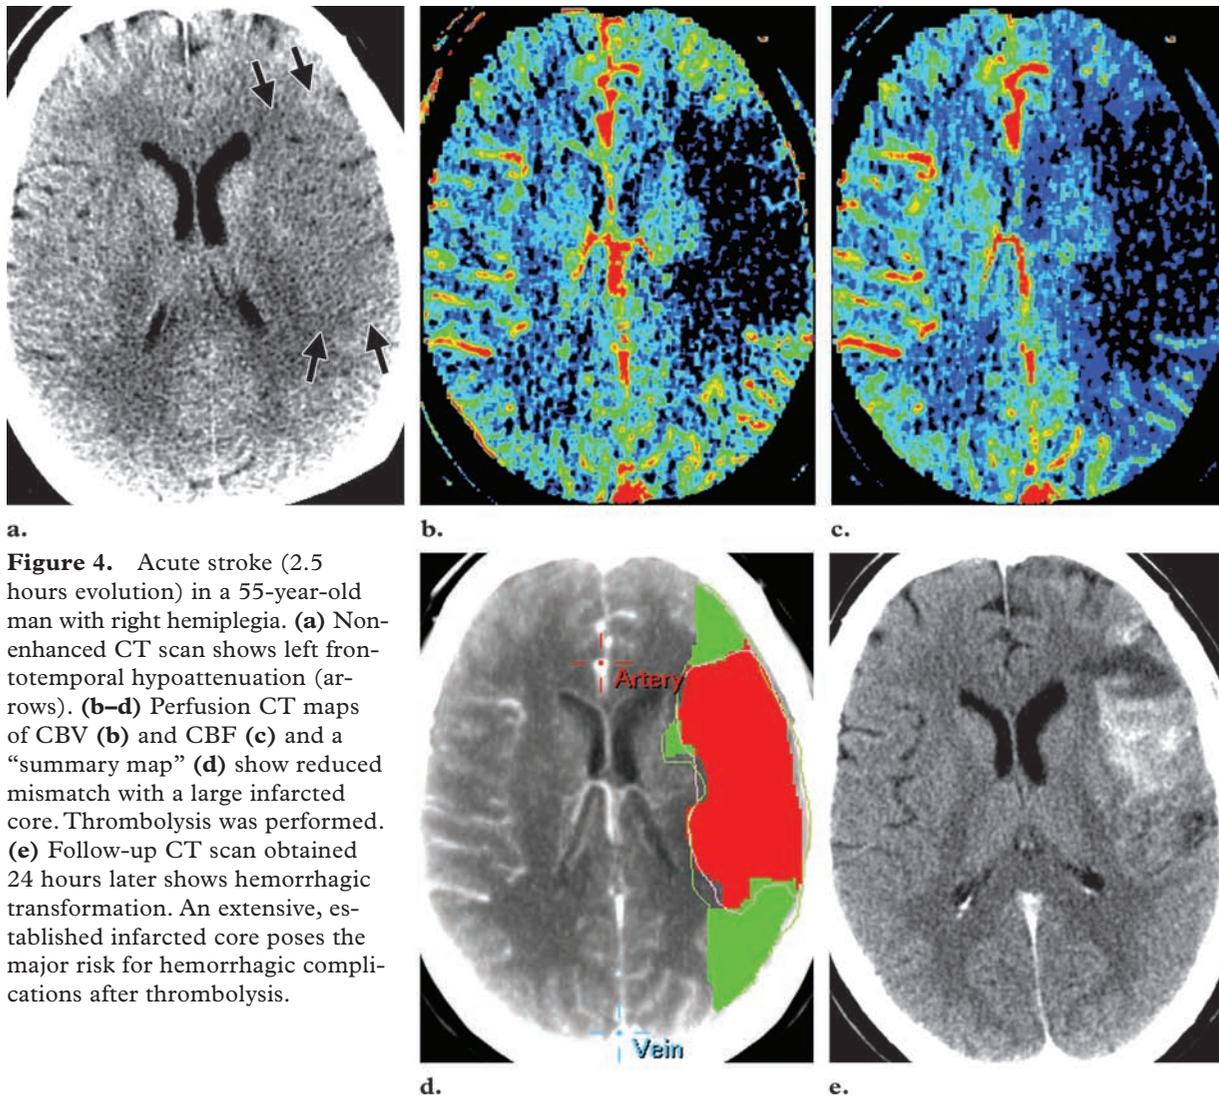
Acute stroke (2.5 hours evolution) in a 55-year-old man with right hemiplegia. (a) Non-enhanced CT scan shows left frontotemporal hypoattenuation (arrows). (b–d) Perfusion CT maps of CBV (b) and CBF (c) and a “summary map” (d) show reduced mismatch with a large infarcted core. Thrombolysis was performed. (e) Follow-up CT scan obtained 24 hours later shows hemorrhagic transformation. An extensive, established infarcted core poses the major risk for hemorrhagic complications after thrombolysis.
